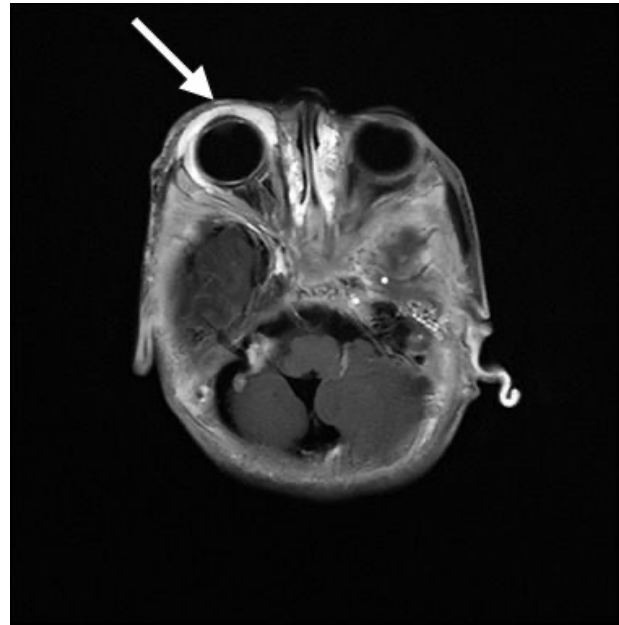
Coronal T1-weighted contrast-enhanced MRI revealing avid, homogeneous enhancement of the lesion.
